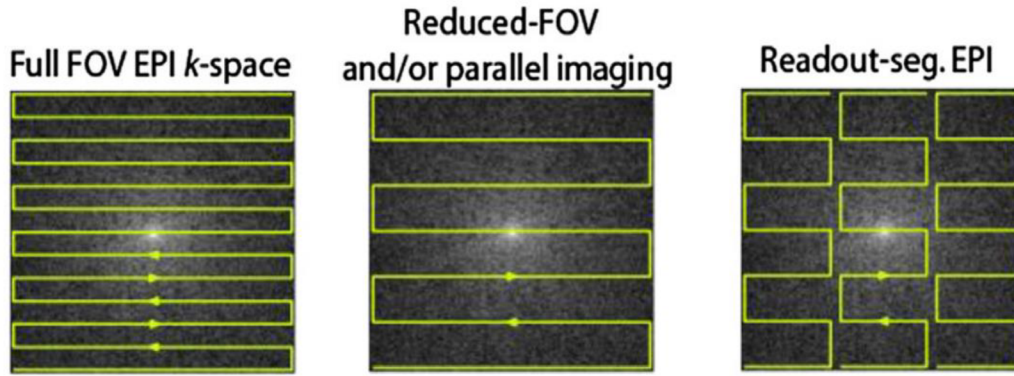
MRI sequences used to accelerate k-space filling to reduce susceptibility induced distortions in echo planar imaging (EPI). From left – sequence without acceleration, reduced field-of-view (FOV) technique, readout-segmented EPI method. Adapted from (Cohen-Adad and Wheeler-Kingshott, 2014).
